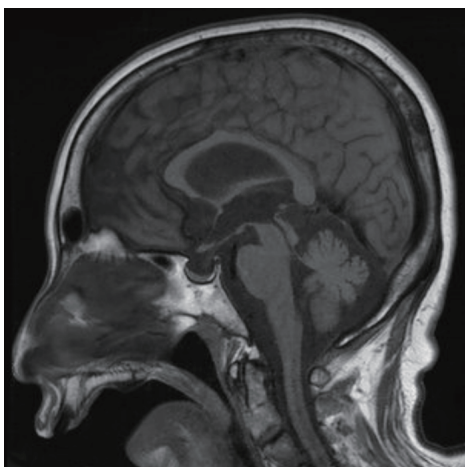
Marked cerebellar atrophy in Brain MRI.
